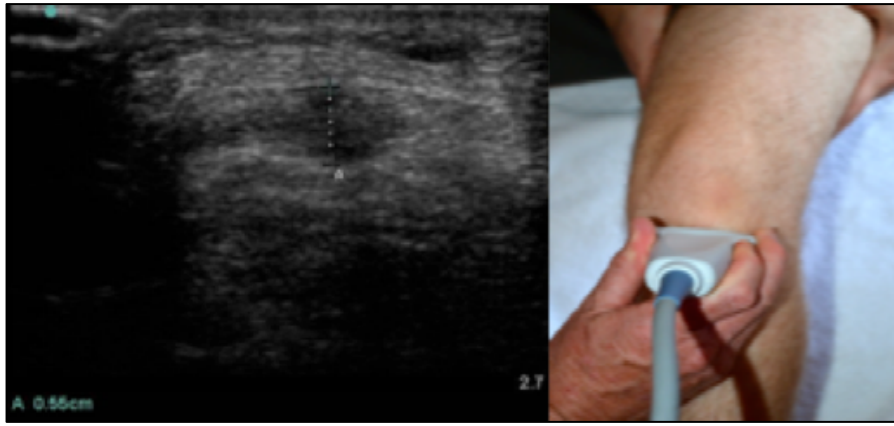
Orientation of the ultrasound transducer to visualise the tendon belly in the transverse plane
